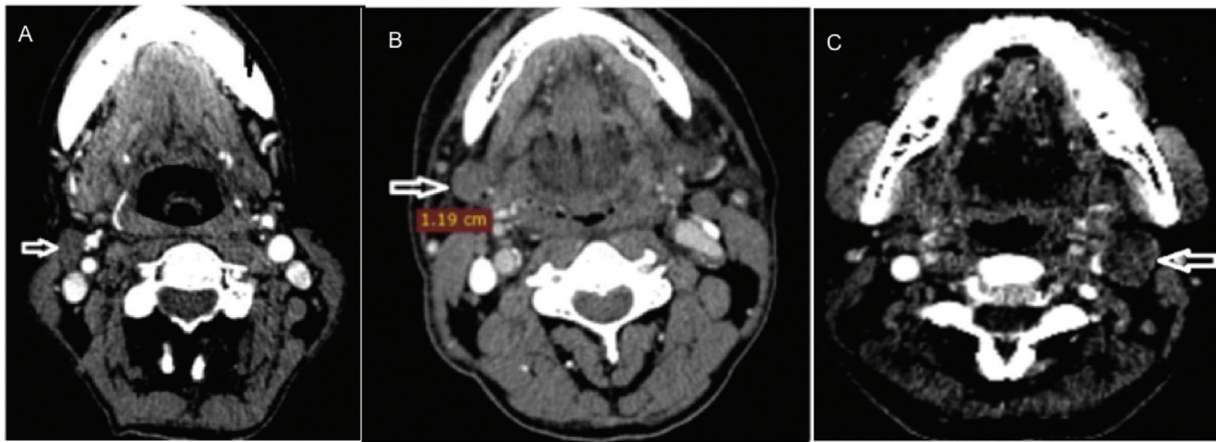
Neck Imaging-Reporting and Data System (NI-RADS). Follow-up computed tomographic scans of patients at 3 months after completion of radiotherapy showing (A) small less than 1 cm lymph node (NI-RADS 1) (arrow), negative for nodal recurrent disease; (B) marginally enlarging lymph node (arrow) without significant postcontrast enhancement (NI-RADS 2), negative for nodal recurrent disease; and (C) significantly enlarging lymph node (arrow) with central necrosis (NI-RADS 3), positive for nodal recurrent disease.
